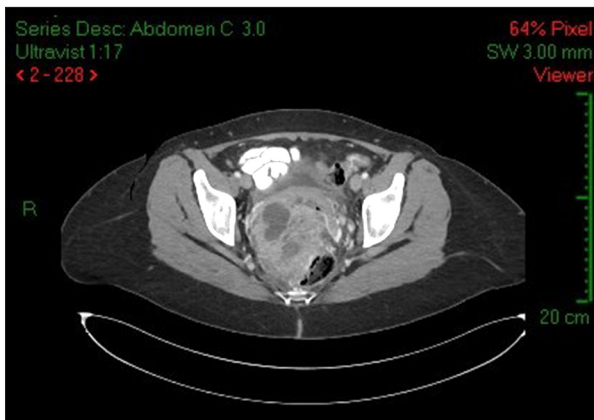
Computed tomography (CT) imaging in the transverse plane. Abdominal and pelvic computed tomography (CT) shows a non-homogenous mass in the recto-uterine pouch, measuring 72×84×103 cm, resulting in anterior pressure on the vagina and posterior pressure on the rectum, but with no signs of obstruction.
